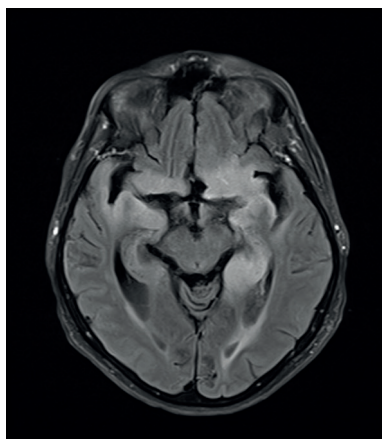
Panel C. Brain MRI MRI on admission day 31, illness day 32: further progression of bilateral T2-hyperintensity and swelling in the frontotemporal lobes and limbic system.
